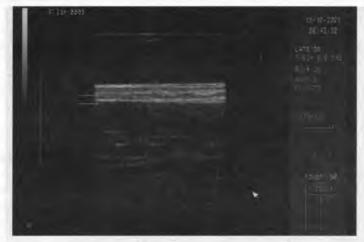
Ultrasonic image of normal skin. The dermis and subcutaneous tissue are marked with arrows
